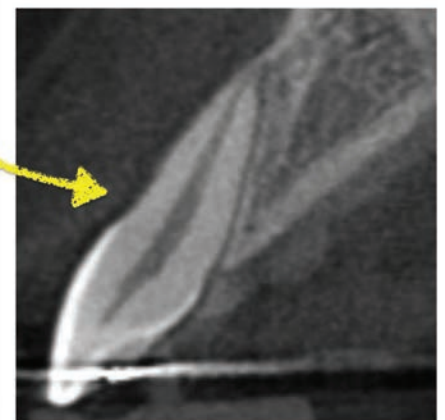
Post treatment CBCT confirming presence of buccal plate - Courtesy Duncan Brown 2015
